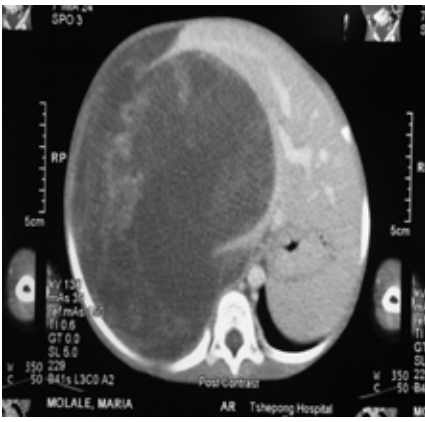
CT appearance of a large mesenchymal hamartoma in the right lobe of the liver
